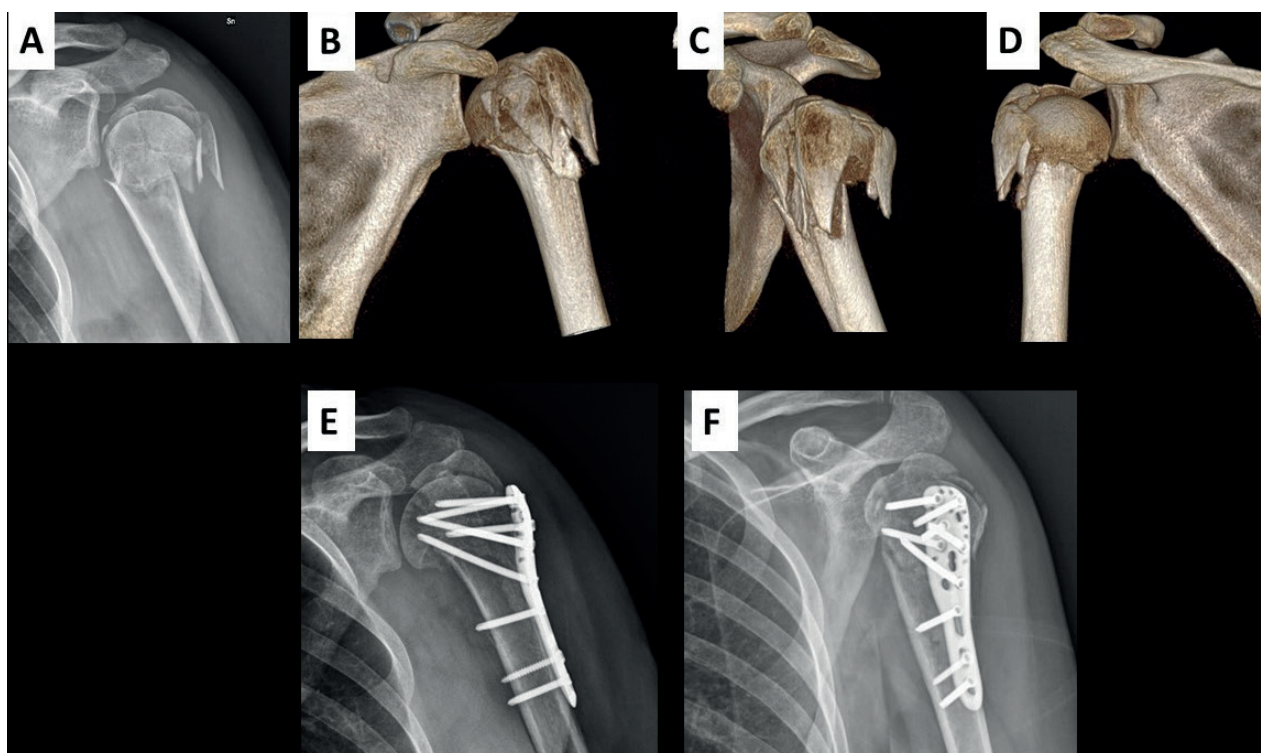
Clinical case 1: Male, 61 years old. Proximal humeral fractures Neer 4 treated by ORIF using deltopectoral approach (DPA). (A) Preoperative anteroposterior X-Rays (XR); (B-D) 3D CT-scan Anterior/Lateral/Posterior views; (E-F) Postoperative XR AP and LL views. The use of this surgical approach succeeded in the humeral head-shaft angle restoration, but not the in greater tuberosity reduction (> 5 mm of residual displacement).
